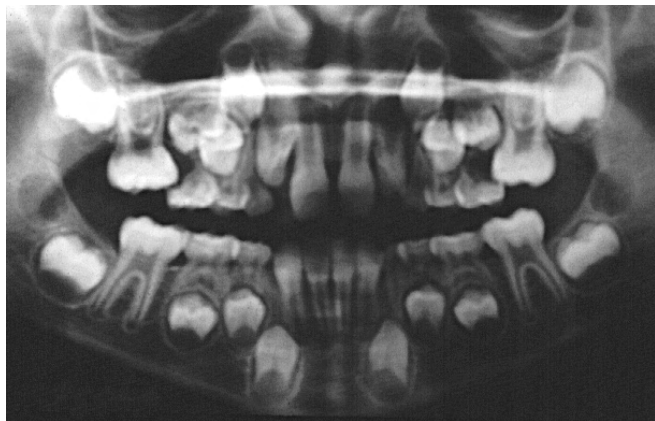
Panoramic radiograph of a child in whom the maxillary permanent first molars have accentuated mesial crown tipping, with eruptive paths that have lysed the distal roots of the primary second molars. This leads to premature loss of the primary molars, followed by mesial drift of the permanent molars that, in turn, reduces space in the midarch that precludes normal eruption of the second premolars. Mesial inclination of the permanent first molars is appreciably more common in the maxilla.
